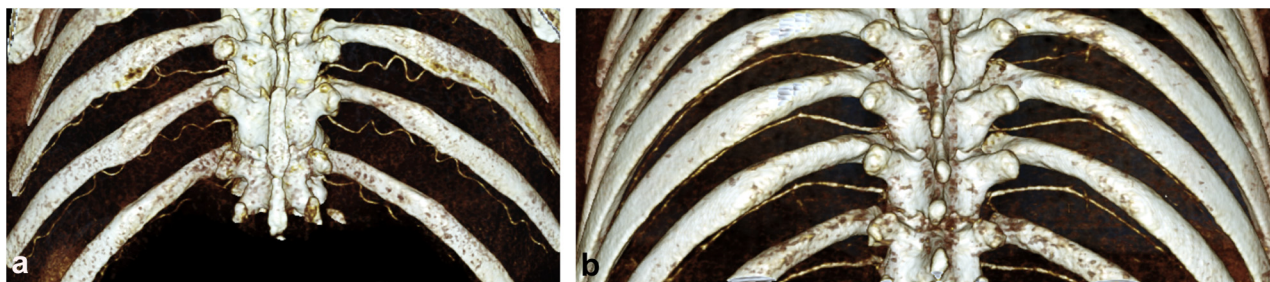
Age-dependent tortuosity of the paravertebral intercostal arteries depicted by surface reconstructions of computed tomography angiograms: (a) a 75-year-old patient demonstrated redundancy, tortuosity, and incursion into the lower half of the intercostal space more laterally, resulting in smaller zones of theoretical low-risk for intercostal puncture, compared with (b) a 35-year-old patient.
